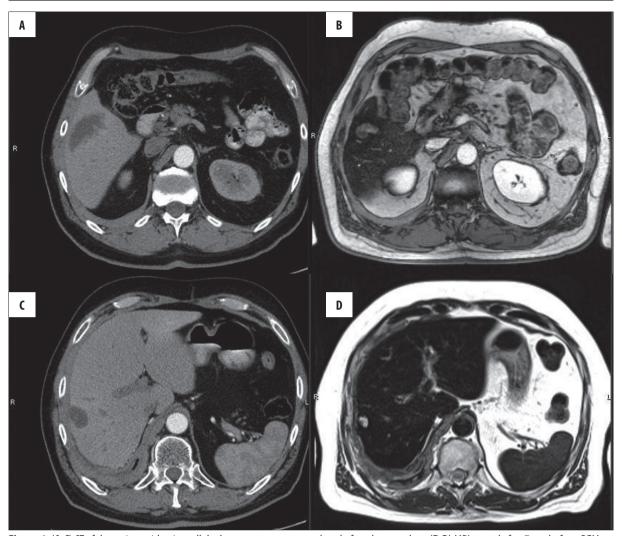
(A,C) CT of the patient with microcellular lung cancer metastases done before the procedure, (B,D) MRI control after 7 weeks from DEM TACE with regression of the lesions.
